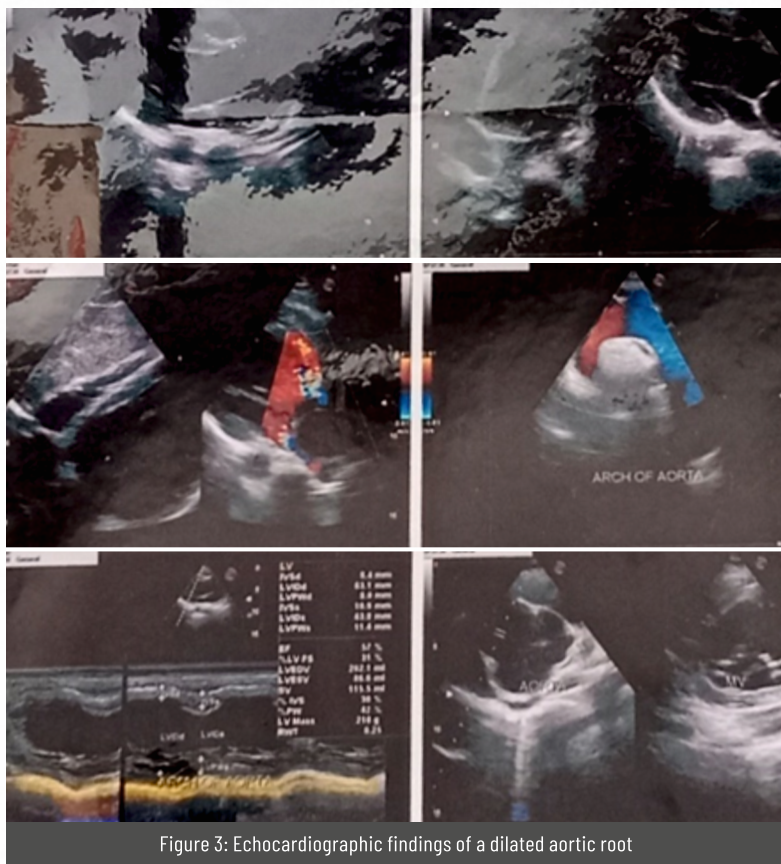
Echocardiographic findings of a dilated aortic root
